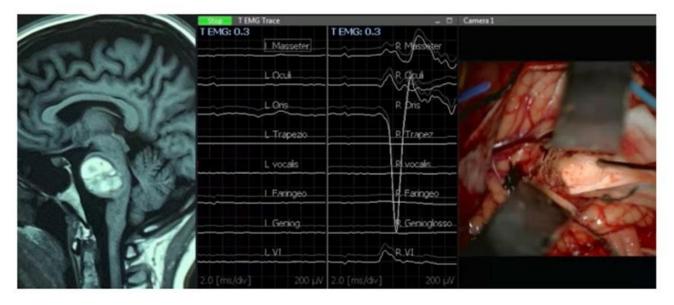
Pre-operative MRI and neurophysiological mapping of the floor of the fourth ventricle
